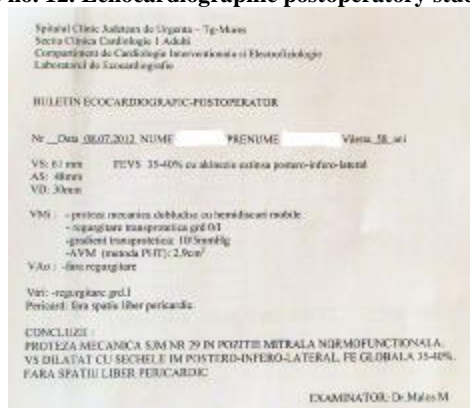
Echocardiographic postoperative study
